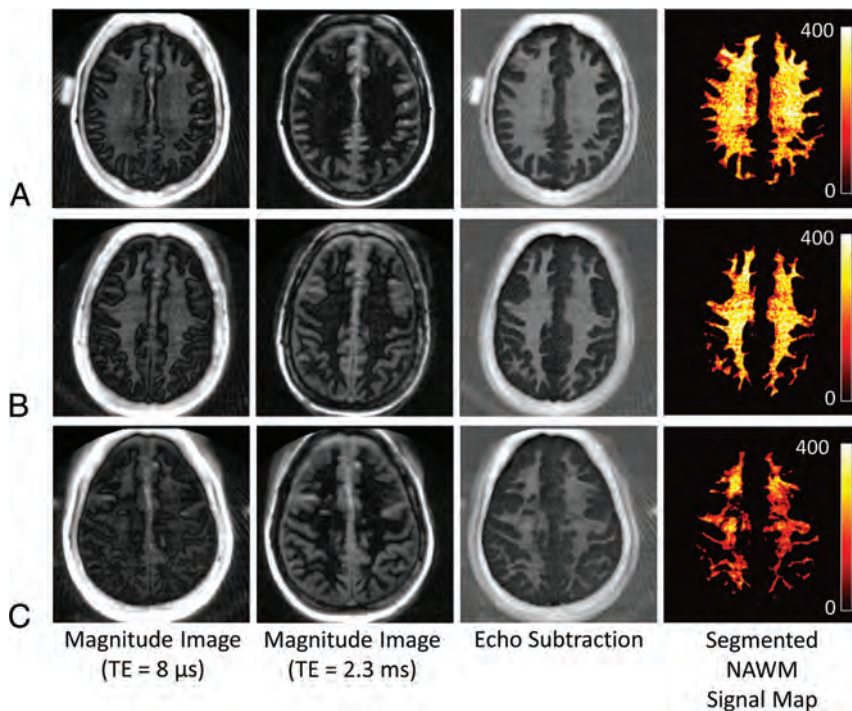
IR-UTE images and NAWM map. These show first-echo IR-UTE images (TE = 8 μ s) in the first column, second-echo images (TE = 2.3 ms) in the second column, and echo-subtraction images in the third column with the corresponding NAWM maps in the fourth column for a healthy volunteer (a 49-year-old man: A, upper row), a patient with MS with an EDSS score of 2 (a 56-year-old man: B, middle row), and a patient with MS with an EDSS score of 6 (a 46-year-old woman: C, lower row). The 2D IR-UTE images are in the native domain, which is different from the MPRAGE and T2-FLAIR images, which are in the normalized template domain.
